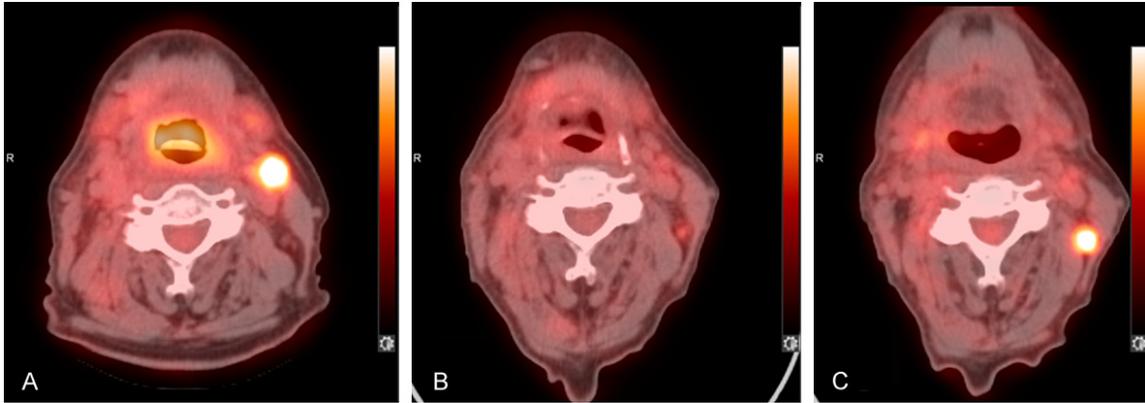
FDG PET/CT imaging of the same patient at diagnosis (A), following radiation therapy (B) and a short term follow-up (4 months later) (C) shows progression of metastatic disease.
